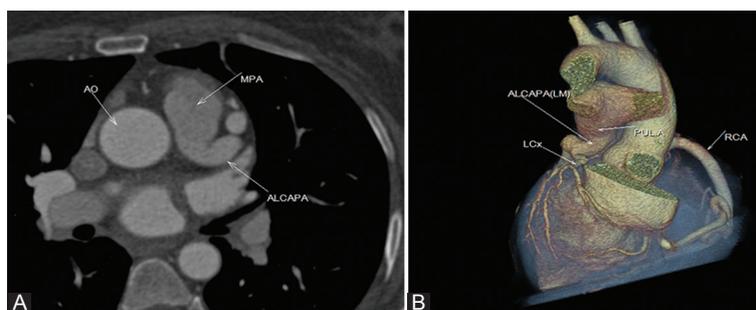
Computed tomographic angiography (A) and three-dimensional computed tomographic angiography (B) show anomalous left main coronary artery arising from the main pulmonary artery.
